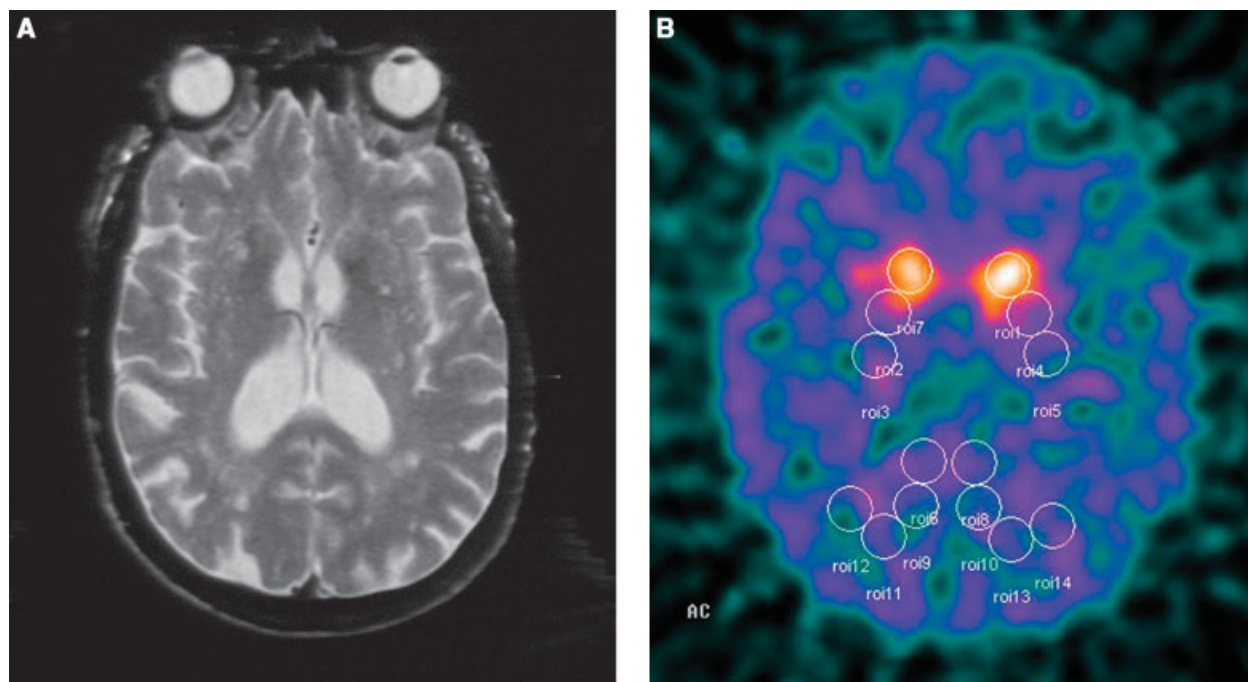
(a) T2 weighted axial MRI scan of a 77-year-old VPI patient with a slowly, progressive frontal gait disorder showing vascular lesions diffusely in the white matter and bilaterally in the putamen. (b) DAT-SPECT scan of this patient showing striatal FP-CIT uptake reduction in a similar distribution as in PD, only less asymmetrical.
